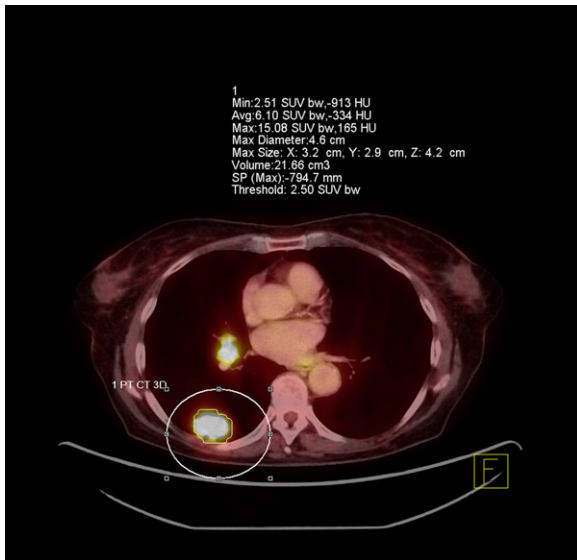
PET–CT scan – delineated tumor (white line) is visible as a high-signal mass comprising the peripheral part of the lung. The calculated isoSUV2.5 volume of primary tumor, without N1 mass, is shown.
